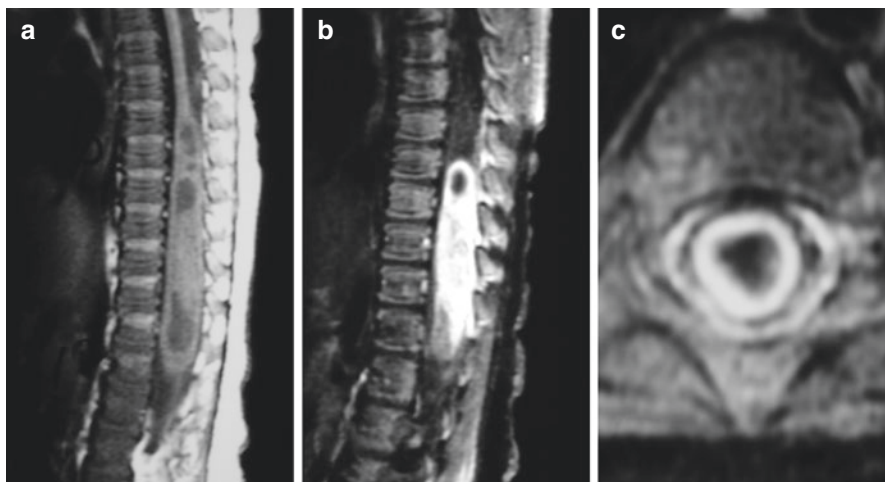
Thoracic anaplastic astrocytoma. MRI of the thoracic cord showing sagittal (a, b) and axial (c) views of relatively heterogeneous enhanced tumor with areas of ring enhancing tumor. Enhancement tends to be patchy in many cases
